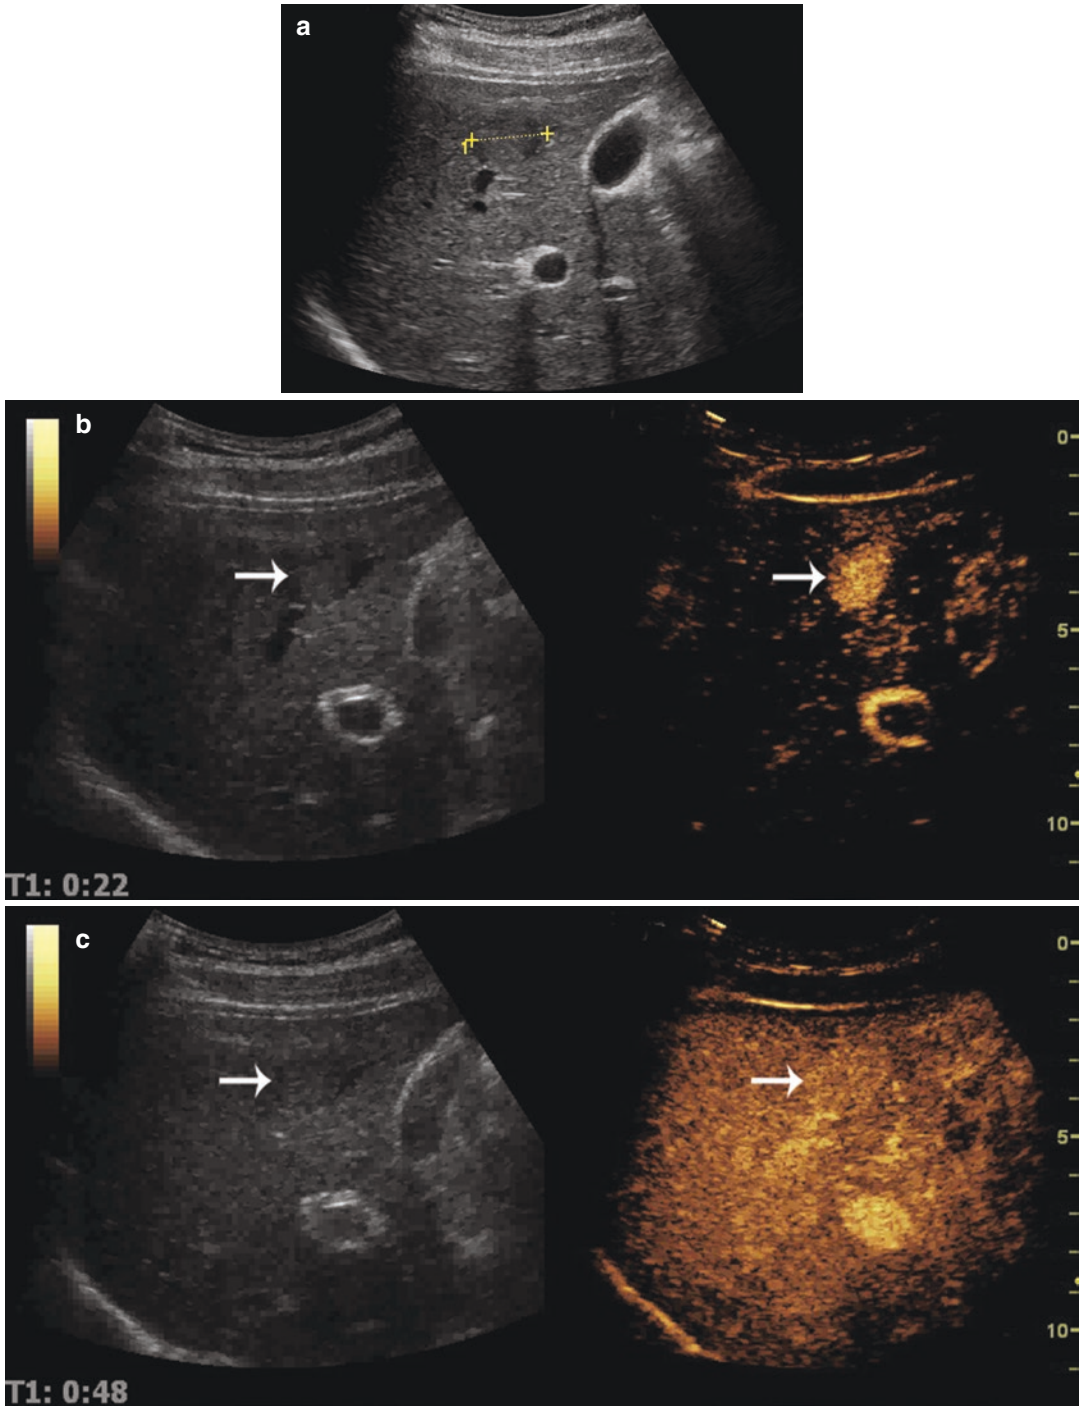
A 3-month-old boy underwent an ultrasound to assess for pyloric stenosis and was incidentally found to have a liver lesion. (a) Sagittal grayscale ultrasound shows a large hyperechoic lesion in segments 5 and 6 of the liver (arrows). (b) Sagittal contrast-enhanced ultrasound (CEUS) image obtained in early arterial phase shows
